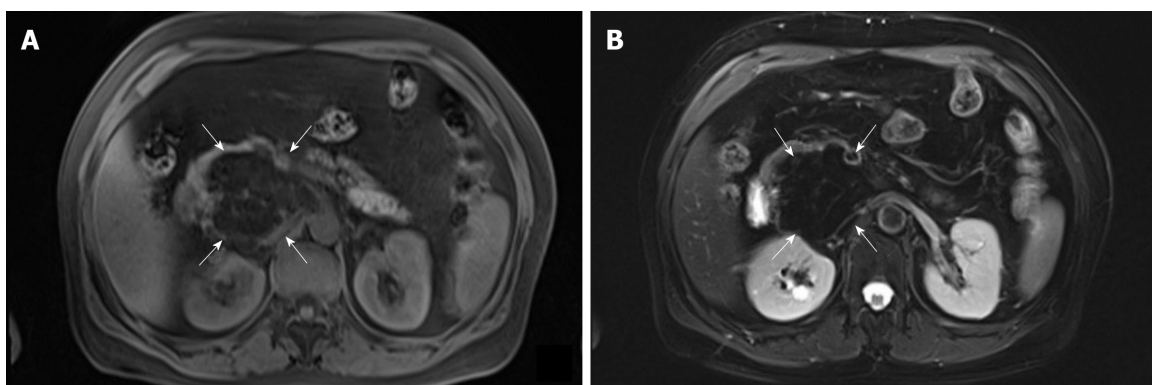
Magnetic resonance scans before treatment. A and B: Both fat-suppressed T1-weighted and fat-suppressed T2-weighted images showed a loss in signal intensity (arrow), which indicated the mass mainly composed of adipose tissue. And a few fibroreticular septa could be seen within the lesion. The boundary between the lesion and the pancreas was unclear.
